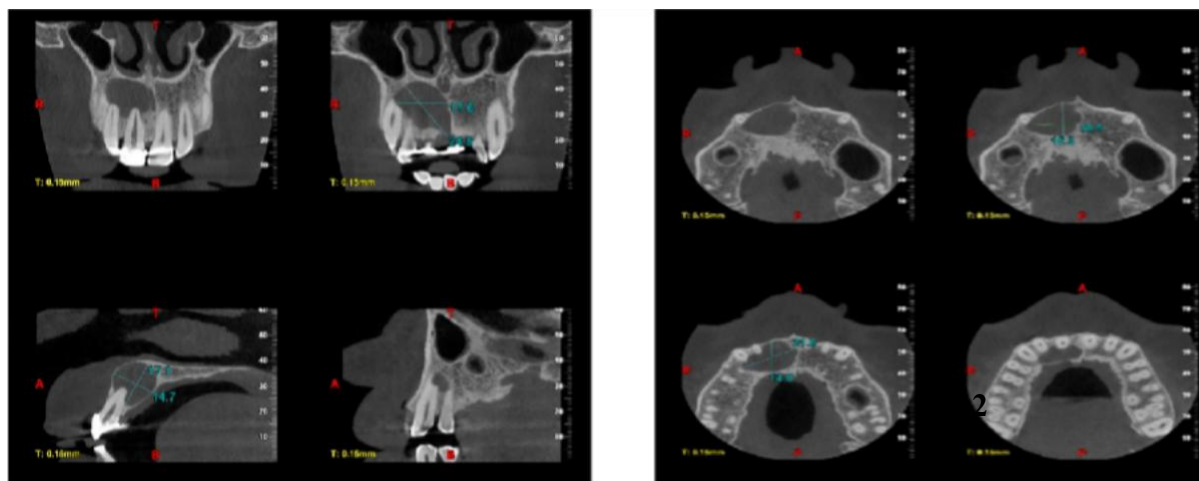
Cone Beam – Computed Tomography
